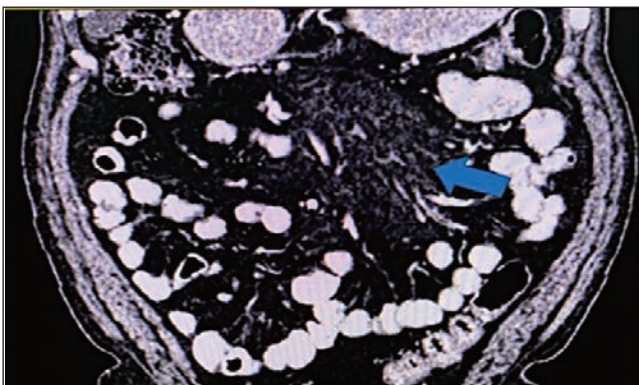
CT scan of the abdomen with contrast coronal view of Case no. 4 showing significant fat stranding within the mesentery in the mid and left side of the abdomen with few sub-centimetre lymph nodes.
